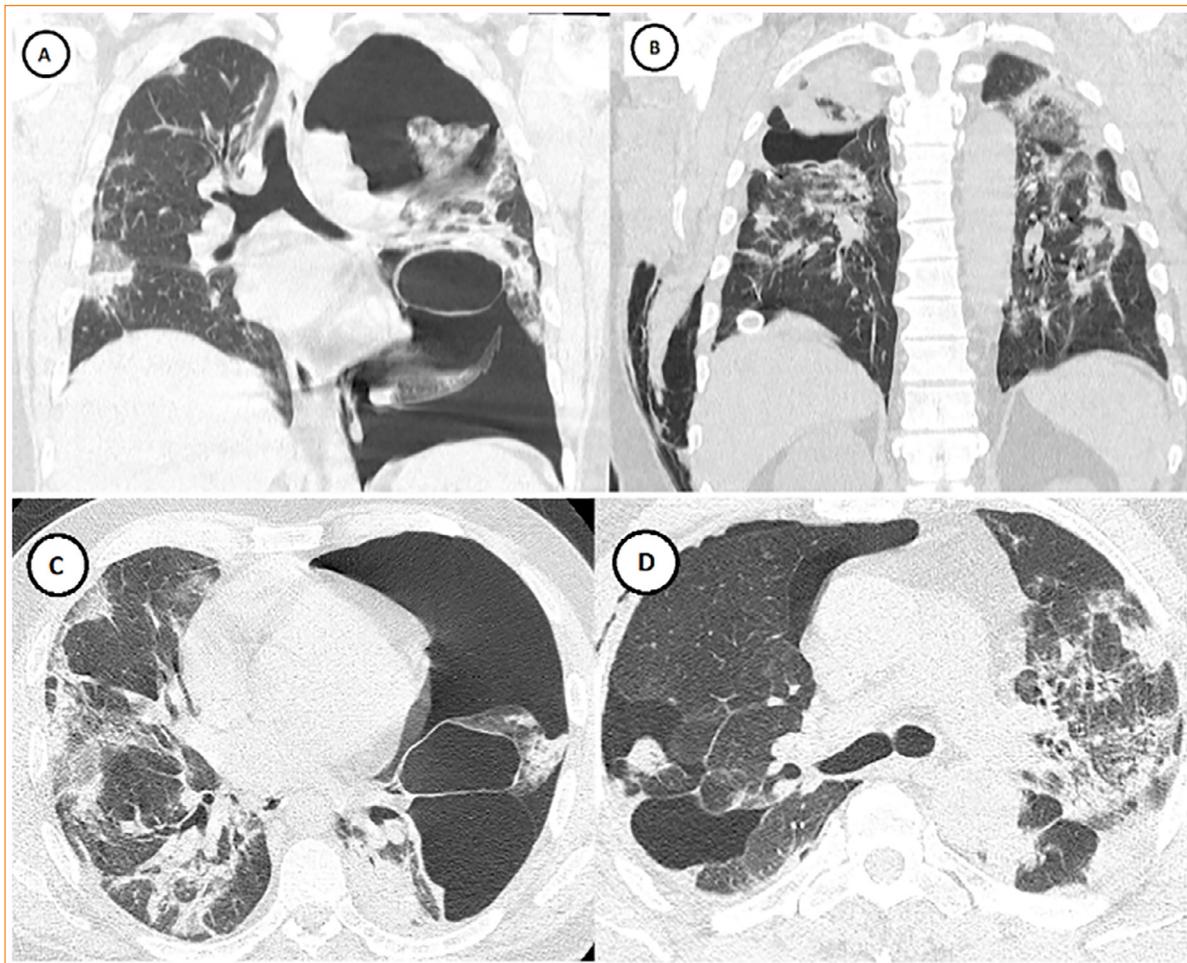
A (coronal reconstruction) and C (axial reconstruction): High-resolution chest computed tomography (HRCT) with pneumothorax on the left side and bilateral consolidations and ground-glass opacities with peripheral predominance; B (coronal reconstruction) and D (axial reconstruction): HRCT with pneumothorax and subcutaneous emphysema on the right side and bilateral consolidations and ground glass opacities.
